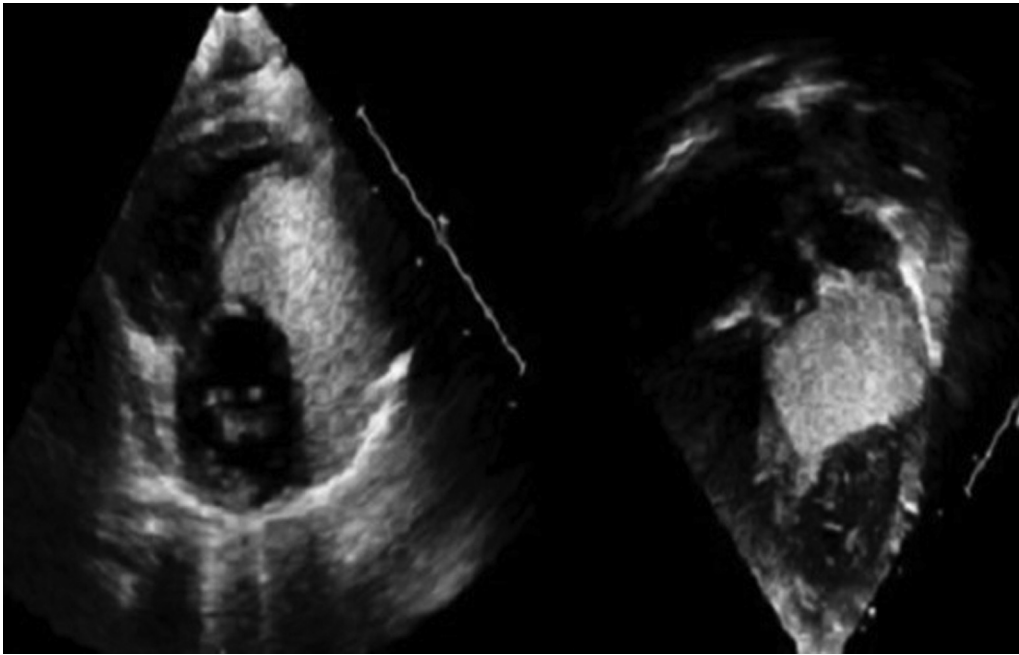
Postnatal echocardiogram showing multiple intramyocardial masses along the interventricular septum (parasternal short-axis view) and on the left ventricular free wall (apical view).
